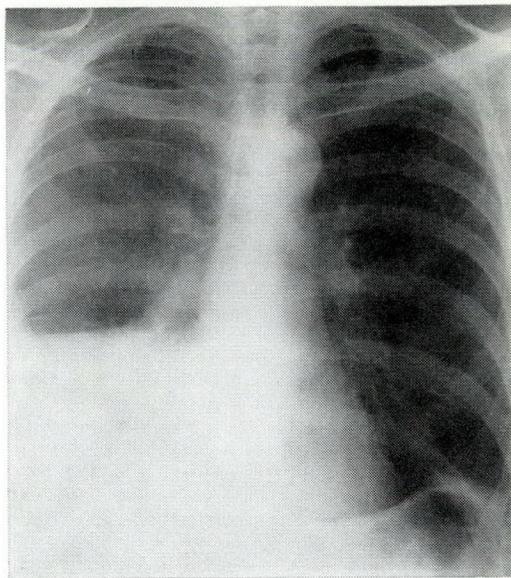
Case 1—pericardial cyst. Postoperative chest radiograph.
